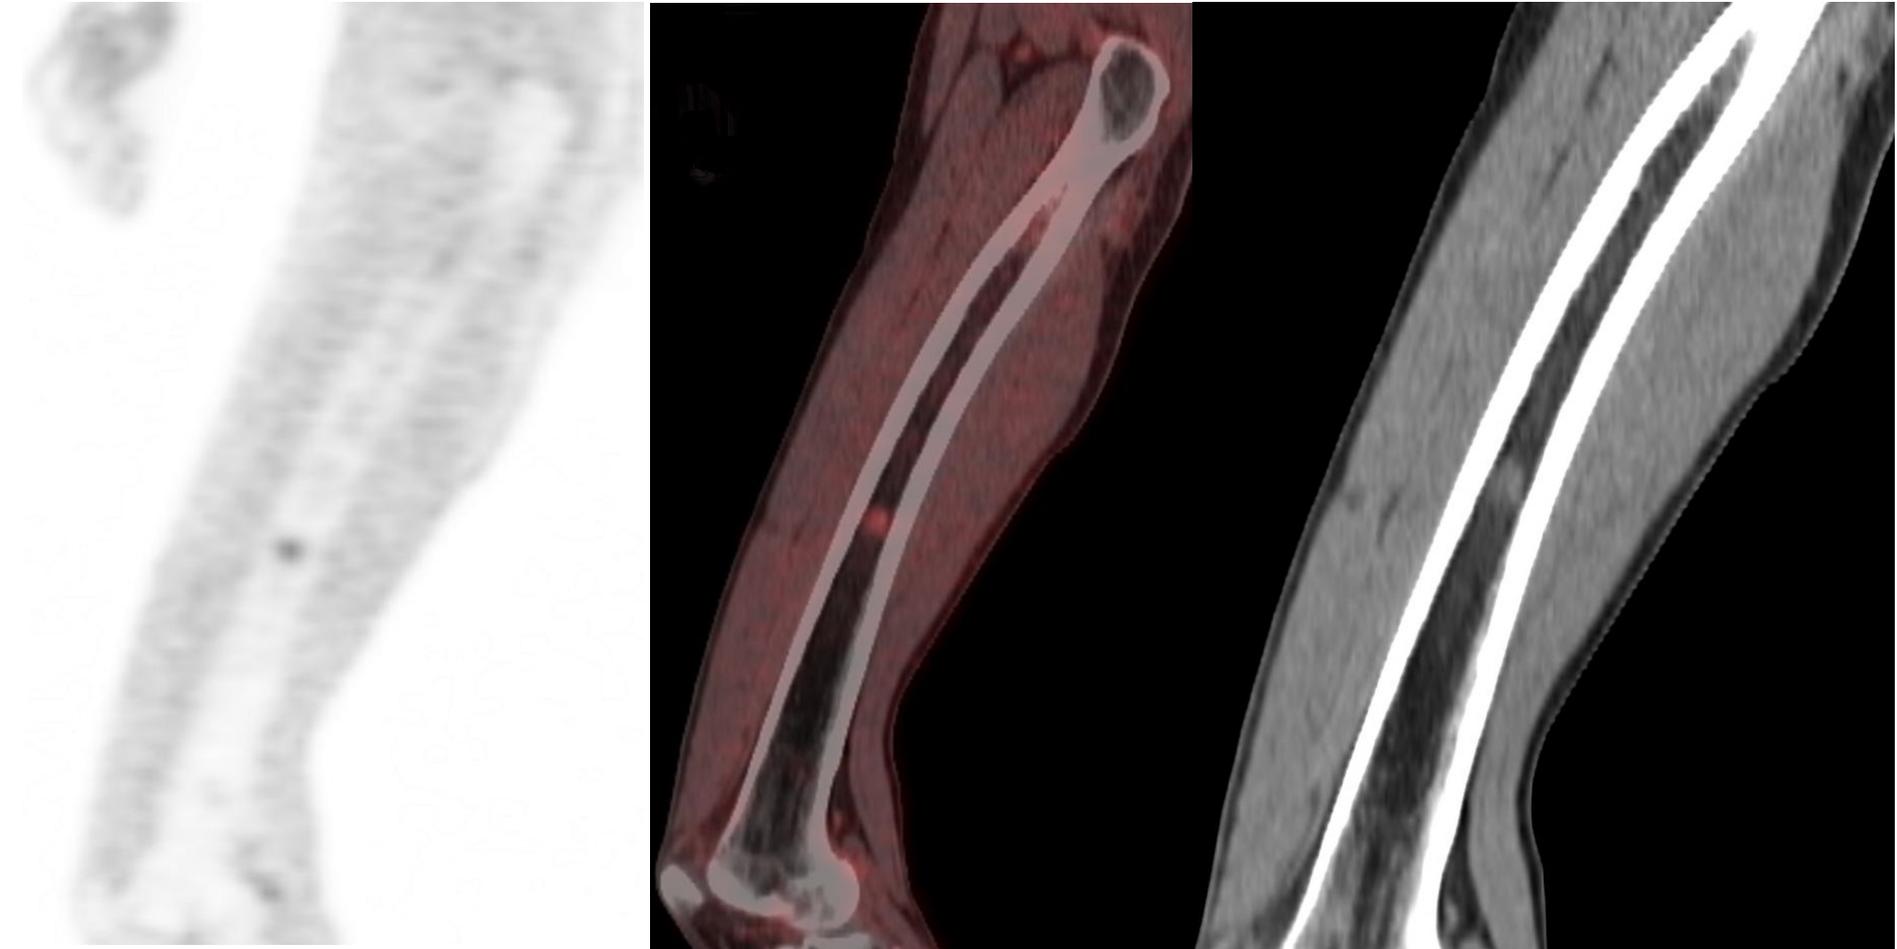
Abbreviations: CT, computed tomography; FL, focal lesion; IQR, interquartile range; PET, positron emission tomography; SUVmax, maximum standardized uptake value.
